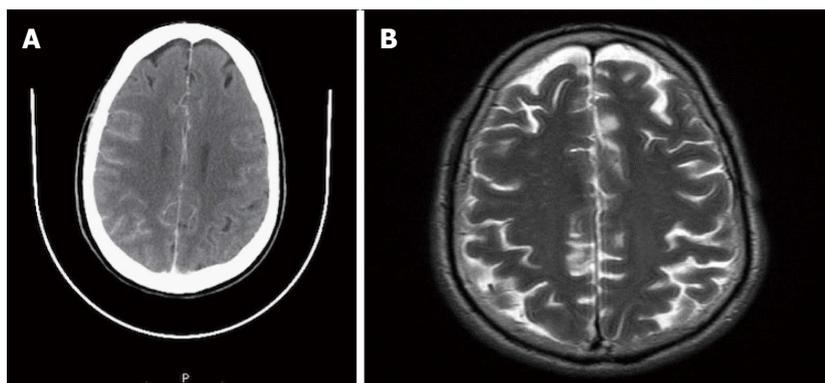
Patient No. 2. A: Computed tomography brain did not reveal brain lesions; B: Magnetic resonance imaging brain showed findings consistent with leptomeningeal carcinomatosis.
